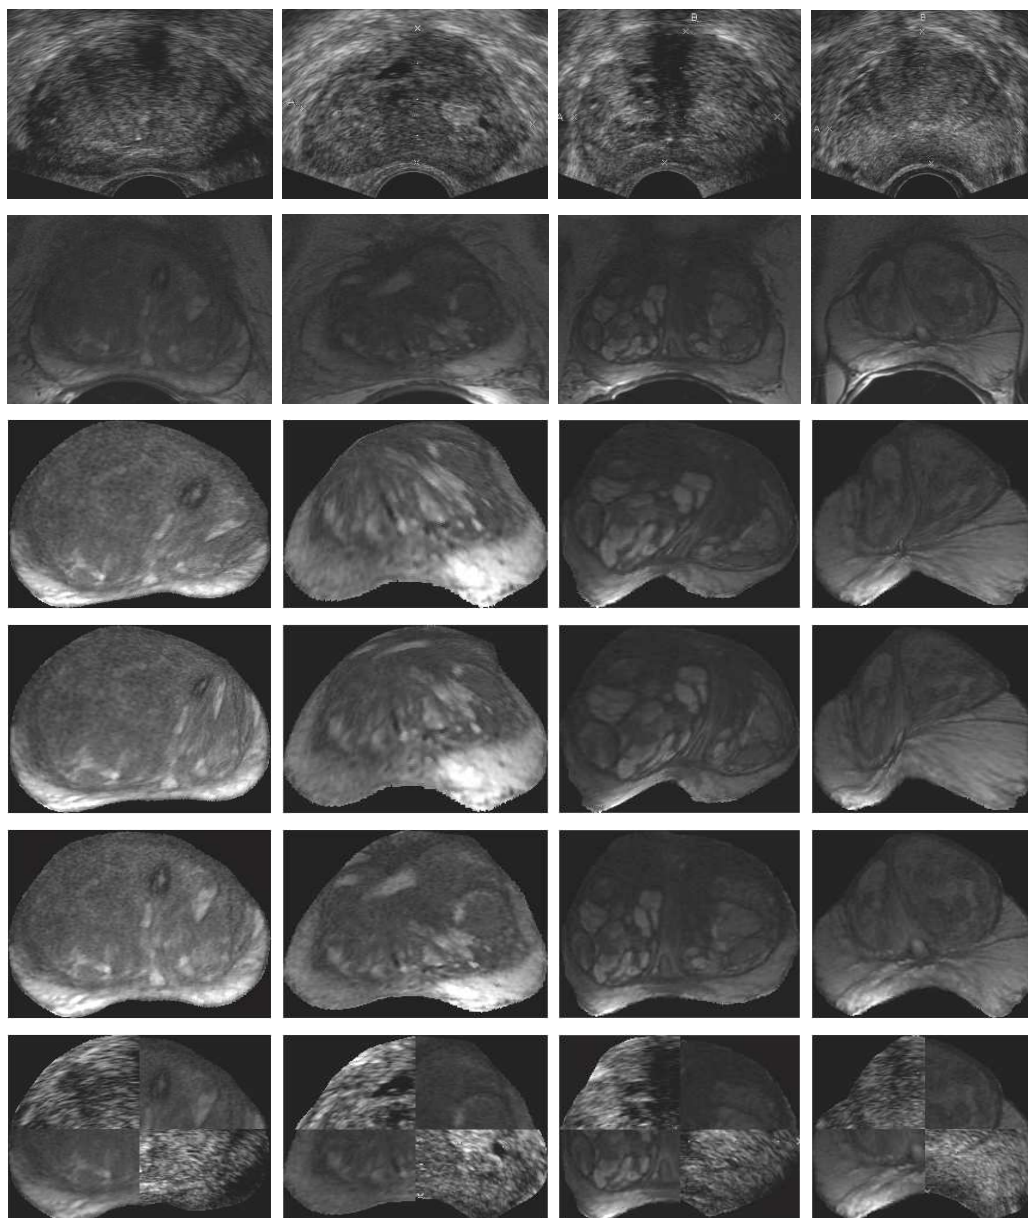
Qualitative registration results of NLTPS-UNI, NLTPS-CORR and NLTPS-REGCORR for patients 7, 8, 11 and 12. Rows 1 and 2 are the fixed TRUS and the moving MR images respectively. Rows 3 and 4 show the transformed MR images for the methods NLTPS-UNI and NLTPS-CORR respectively. Rows 5 and 6 show the transformed MR images and the checker-board of the fixed TRUS and the transformed MR images for the method NLTPS-REGCORR (proposed).
